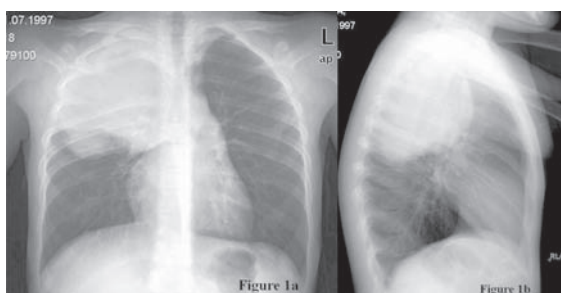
A large mass lesion within the upper right thoracic cavity and lytic bone lesion at the 4th rib were seen by the posteroanterior (a) and lateral (b) chest radiographs.
